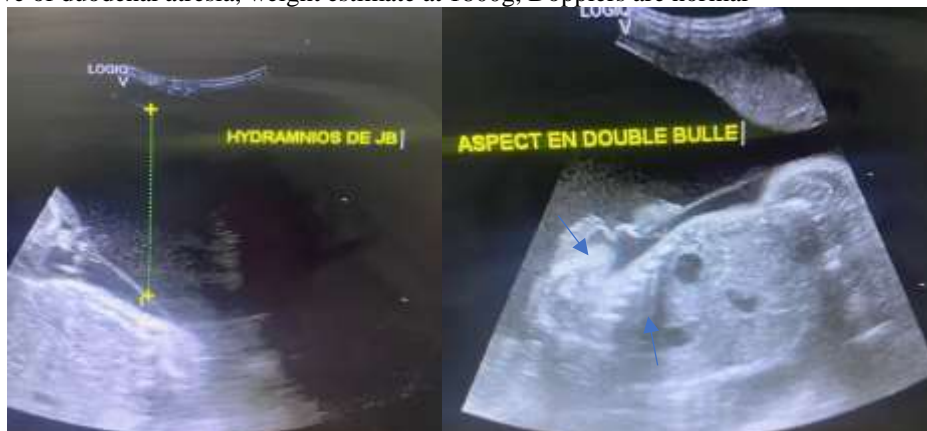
Obstetric ultrasound: Double bubble sign with polyhydramnios
